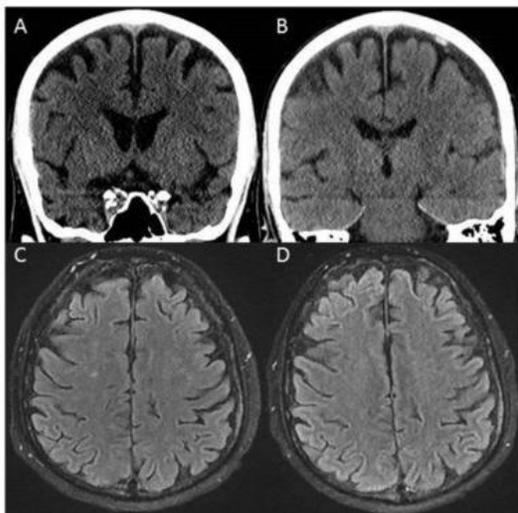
Pre-treatment (A) and post-treatment coronal noncontrast head CT 3 days later (B) in patient with neurotoxicity demonstrating development of bilateral subdural hemorrhage. Different patient (C, D) with axial FLAIR images demonstrating punctate foci of T2/FLAIR hyperintensity in the white matter (C) which resolved 5 days later (D). Other foci of white matter hyperintensity not shown.
